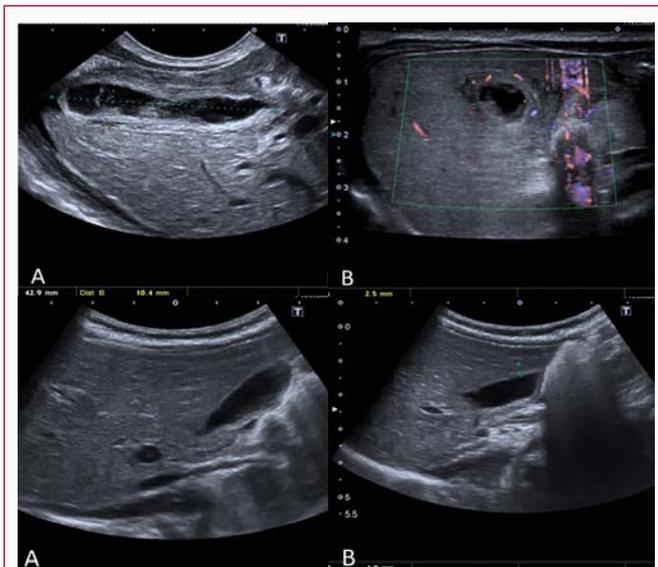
Above: Ultrasound of the gallbladder at the time of diagnosis. A: Longitudinal view of the gallbladder showing marked distention (42.9 mm × 10.4 mm), wall thickening, internal membranes and sludge and some perivesicular fluid at the fundus. B: Transverse view of the gallbladder showing parietal thickening (2.5 mm) with hyperemia, internal membranes and sludge and perivesicular edema. Below: Follow-up ultrasound at 7 weeks showing normalization of the gallbladder which now appears with clear content as well as normal size and wall thickness.
